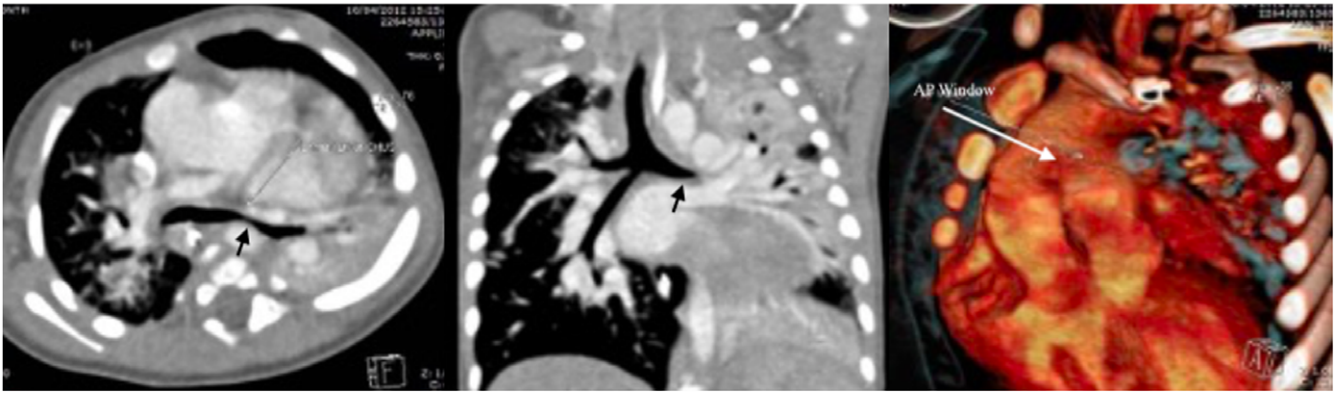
CT scan of 5-month-old girl demonstrates an aortopulmonary window causing massive enlargement of pulmonary artery and aorta. Compression of left main bronchus (arrow) occurred by the descending aorta and left pulmonary artery causing collapse of posterior segment of the left lung.
